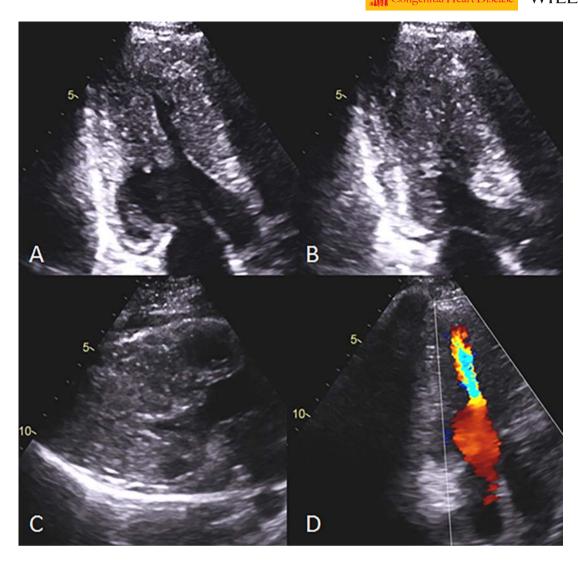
HCM with midventricular obstruction. (A) Apical long axis in diastole demonstrating severe circumferential apical hypertrophy. (B) Apical long axis in systole demonstrating absence of systolic anterior motion (SAM). (C) Parasternal long axis in systole showing cavity obliteration and absence of SAM. (D) Color flow aliasing at the midventricle consistent with midventricular obstruction without significant LVOT obstruction [Color figure can be viewed at wileyonlinelibrary.com]
